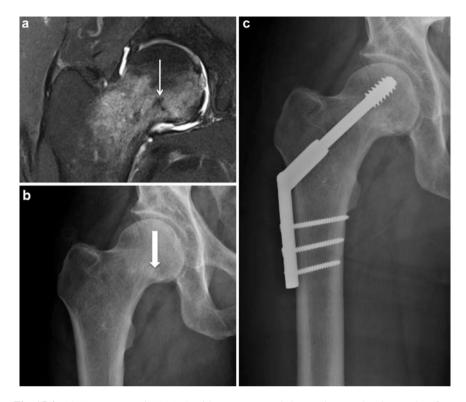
(a) Fat-suppressed T1 MRA with contrast reveals bony edema and an incomplete fracture line in the compression side of the right femoral neck (*thin arrow*). (b) AP radiograph of the right hip from the same time point demonstrates subtle sclerosis in the femoral neck (*thick arrow*). (c) After a course of conservative treatment for the stress fracture failed, surgical fixation was undertaken utilizing a sliding hip screw and side-plate device
